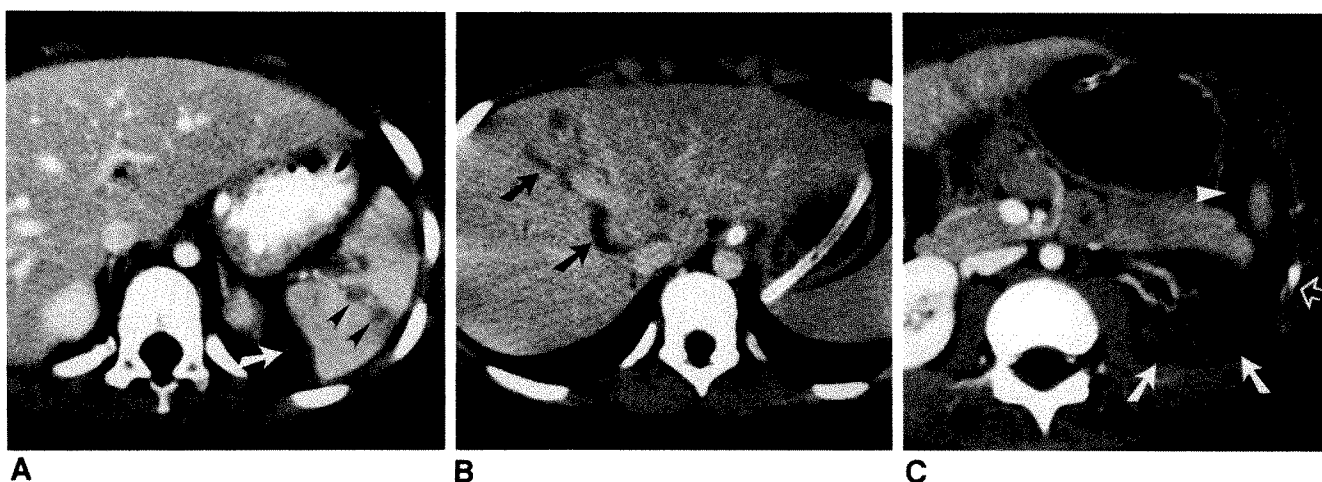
Parenchymal trauma shown on ultrafast CT scans. Imatron C-100, 0.4-sec imaging time with 2 ml/kg IV contrast material.
